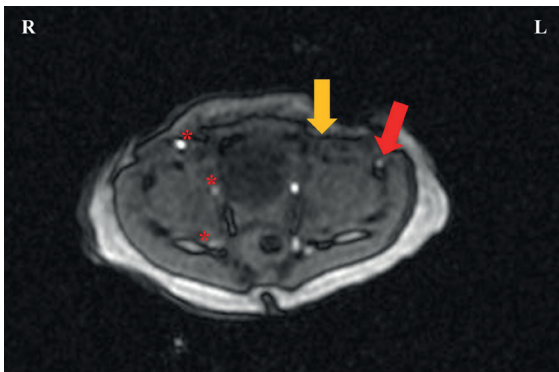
Magnetic resonance angiography (MRA) of the abdominal aorta and pelvic arteries performed on the third day of life shows absent signal in the left external iliac artery (yellow arrow), consistent with severe stenosis, with collateral circulation via circumflex branches (red arrow) and normal right-sided arteries (red asterisks; in order from anterior to posterior: external iliac artery, internal iliac artery, and gluteal arteries). Image quality is limited due to acquisition on a 2-Tesla MRI scanner, the inability to perform MRA under anesthesia, and motion artefacts related to infant movement.
